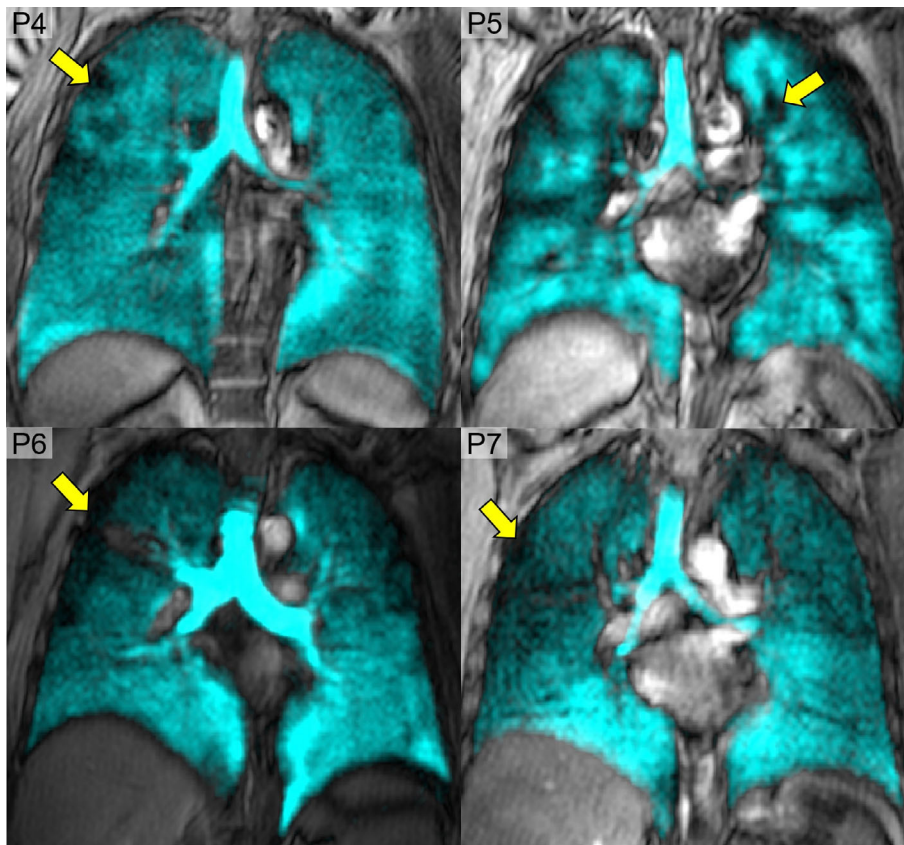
Abnormal ^{129}Xe MRI in participants with long-COVID. Coronal ^{129}Xe ventilation MRI slices (cyan) co-registered with ^1H MRI thoracic cavity in four participants with long-COVID and no previous diagnosis of chronic respiratory disease. Arrows identify ventilation abnormalities. P6 was a 53-year-old female with $\text{FEV}_1 = 84\%$, $\text{DL}_{\text{CO}} = 83\%$, $\text{SpO}_2 = 98\%$, $\text{LCI} = 8$, and $\text{VDP} = 3\%$. P7 was a 73-year-old male with $\text{FEV}_1 = 88\%$, $\text{DL}_{\text{CO}} = \text{ND}$, $\text{SpO}_2 = 98\%$, $\text{LCI} = \text{ND}$, and $\text{VDP} = 10\%$. P8 was a 65-year-old female with $\text{FEV}_1 = 95\%$, $\text{DL}_{\text{CO}} = 97\%$, $\text{SpO}_2 = 98\%$, $\text{LCI} = 9$, and $\text{VDP} = 7\%$. P9 was a 46-year-old male with $\text{FEV}_1 = 106\%$, $\text{DL}_{\text{CO}} = 96\%$, $\text{SpO}_2 = 98\%$, $\text{LCI} = 8$ and $\text{VDP} = 3\%$. ND = not done; SpO_2 = oxygen saturation measured using digital pulse oximetry; LCI = lung clearance index; VDP = ventilation defect percent.
